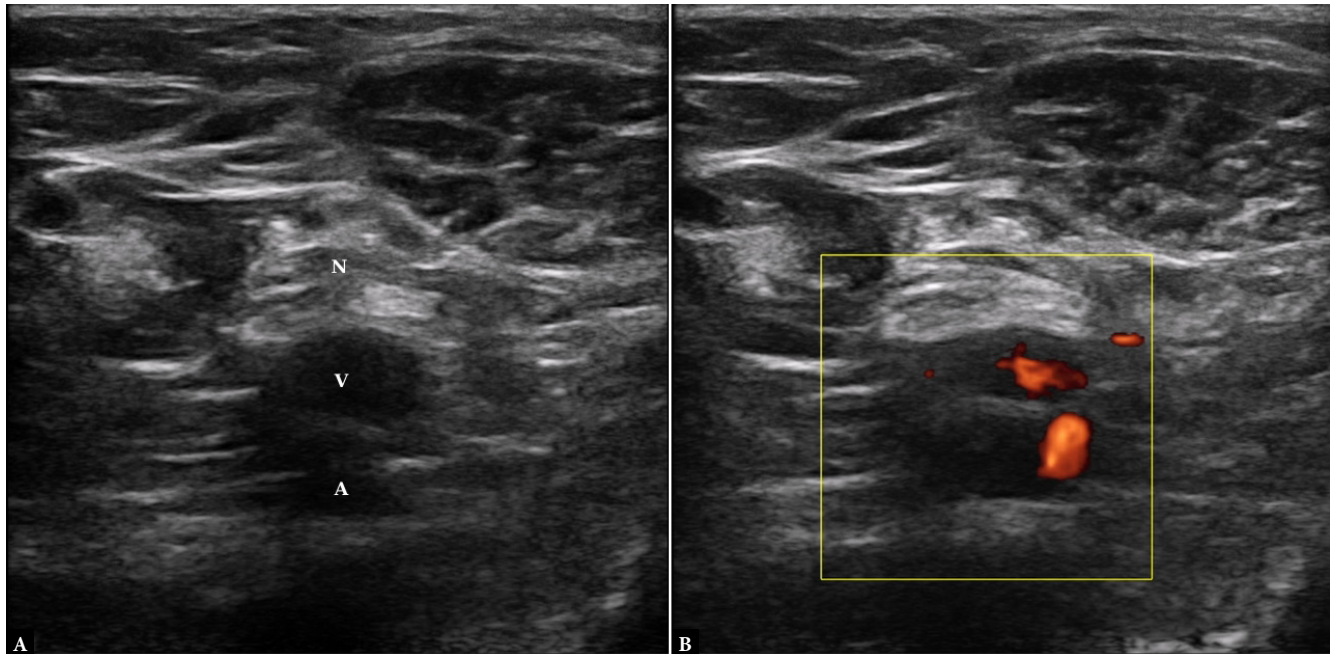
Short-axis ultrasound images of the right popliteal fossa. A. Gray-scale image demonstrating the typical topographic relationship between the sciatic nerve and adjacent vascular structures. B. Power Doppler image at the same level, facilitating differentiation of the artery and vein and confirming the position of the nerve relative to the vessels. N – nerve; A – artery; V – vein
